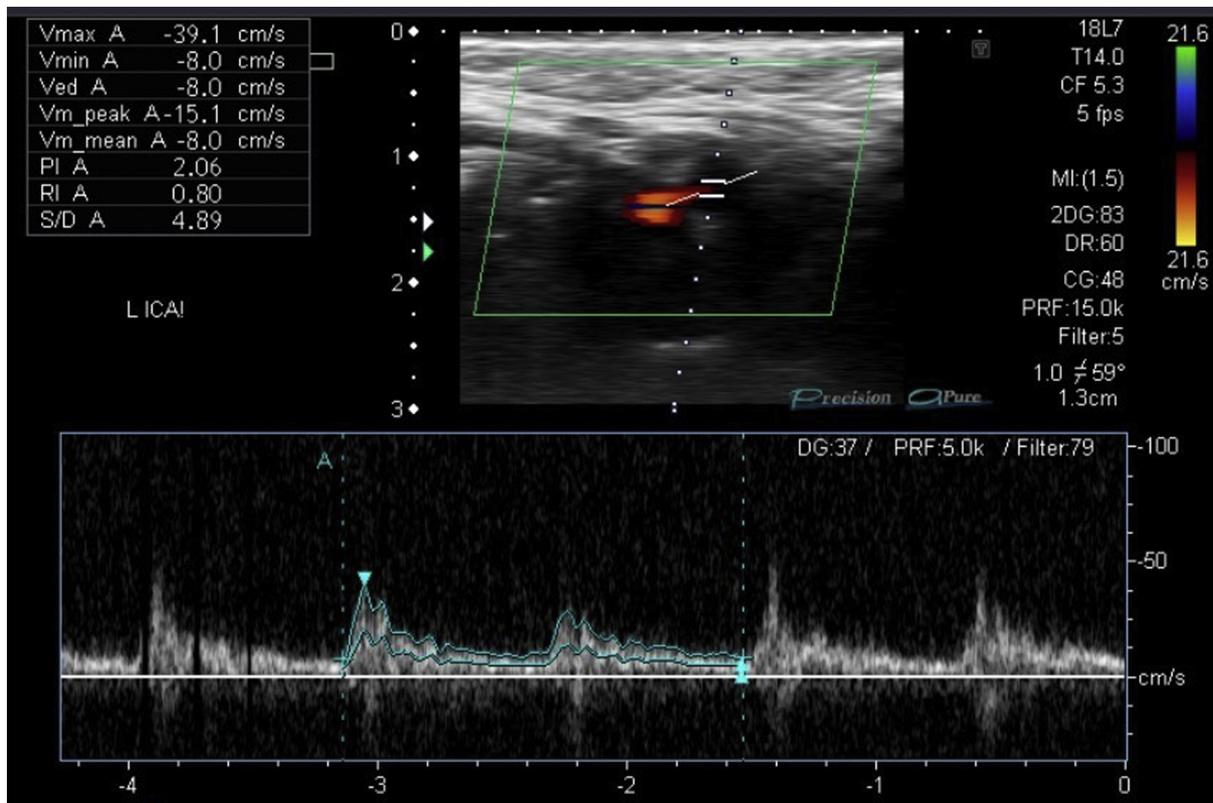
Doppler ultrasonography showed no luminal pathology in the left CCA, ICA, and ECA but increased resistivity index (RI = 0.80) was detected.
